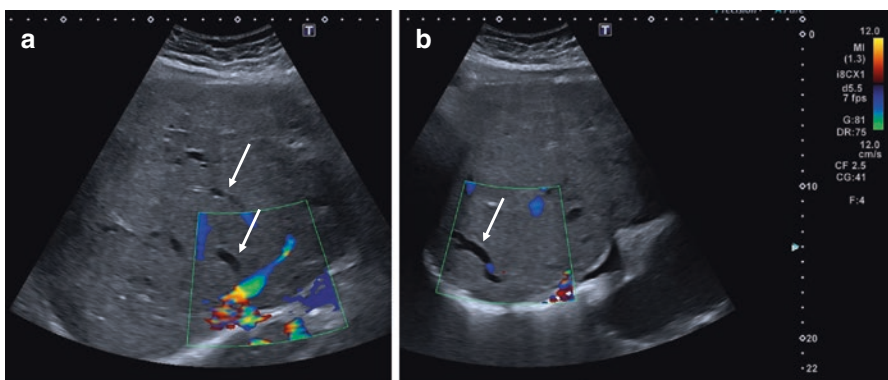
Examples of intrahepatic venous derivations in an asymptomatic 47-year-old female with chronic Budd–Chiari syndrome secondary to myeloproliferative neoplasia. (a–b). Color coded Doppler analysis ultrasound shows intrahepatic venous collaterals (arrows). These collaterals may mimic actual hepatic veins, and frequently follow subcapsular routes
